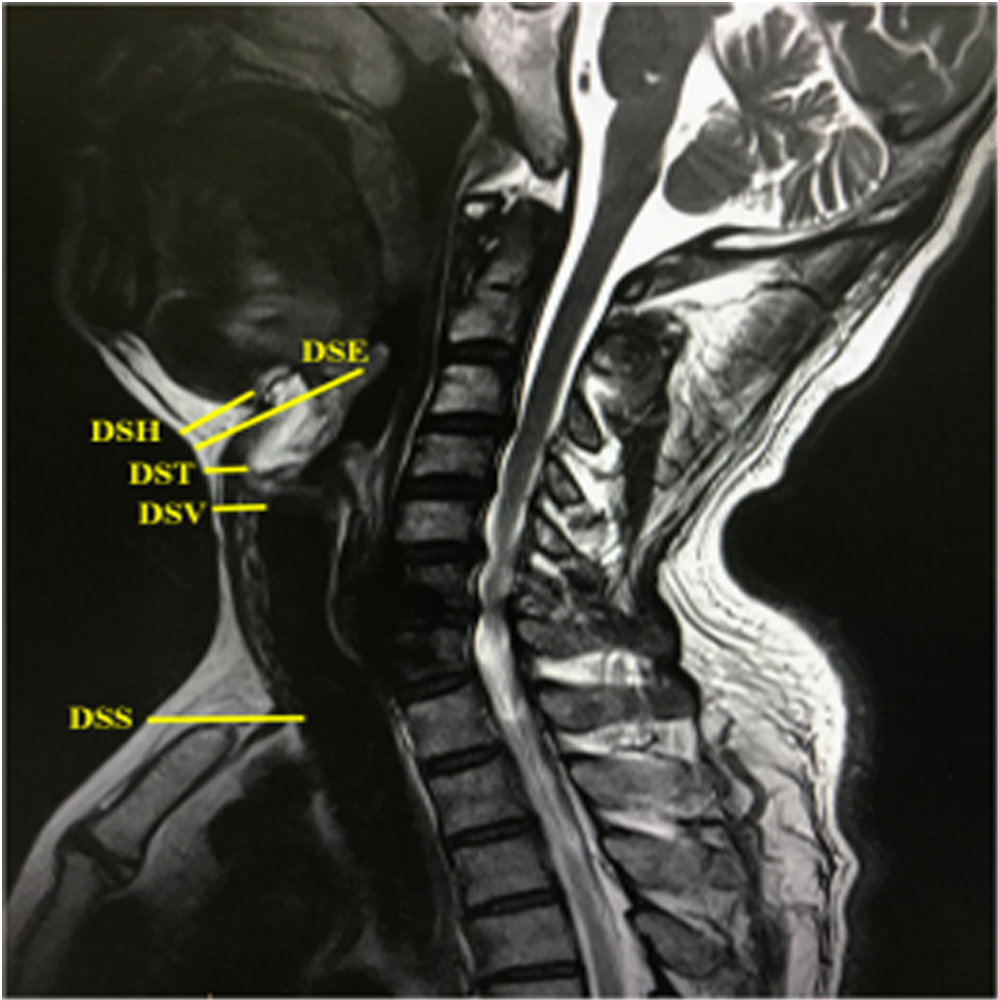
Indicators on lateral sagittal neck MRI image.
